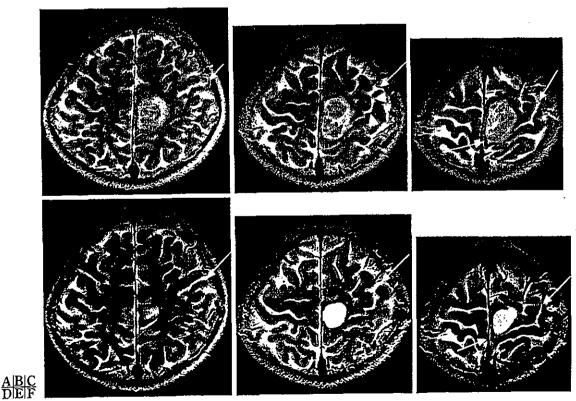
Pre- (A~C) and postoperative (D~F) T2-weighted magnetic resonance images
